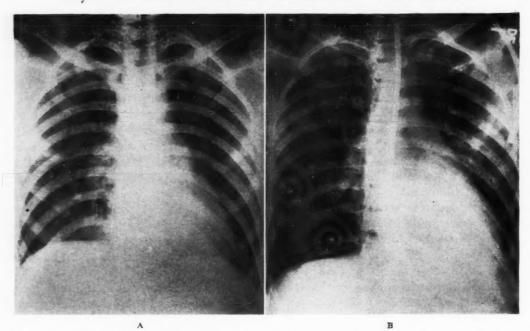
Case I. X-rays taken on admission (A) and four days later (B) showing extension of the soft, nodular densities throughout both lung fields.
